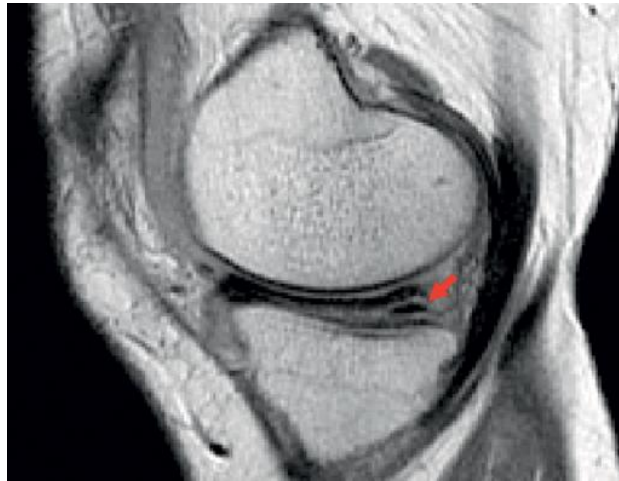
Magnetic resonance imaging of the right knee revealed, T1-weighted sagittal MRI of the right knee visualized medial discoid meniscus with a horizontal tear (confirmed by red arrow)
